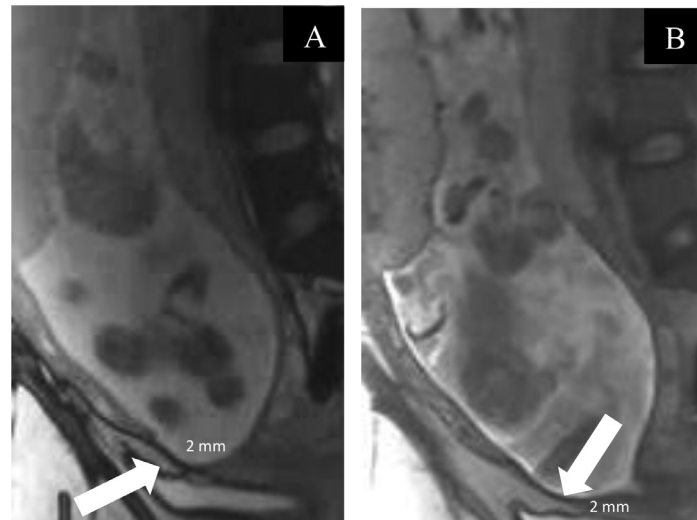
Sagittal steady state free precession (A) and single shot turbo spin echo (B) T2-weighted images of the abdomen and pelvis. Marked thinning of the myometrium is also noted in the lower uterine segment (white arrows) with 1-2 mm of myometrium remaining.
